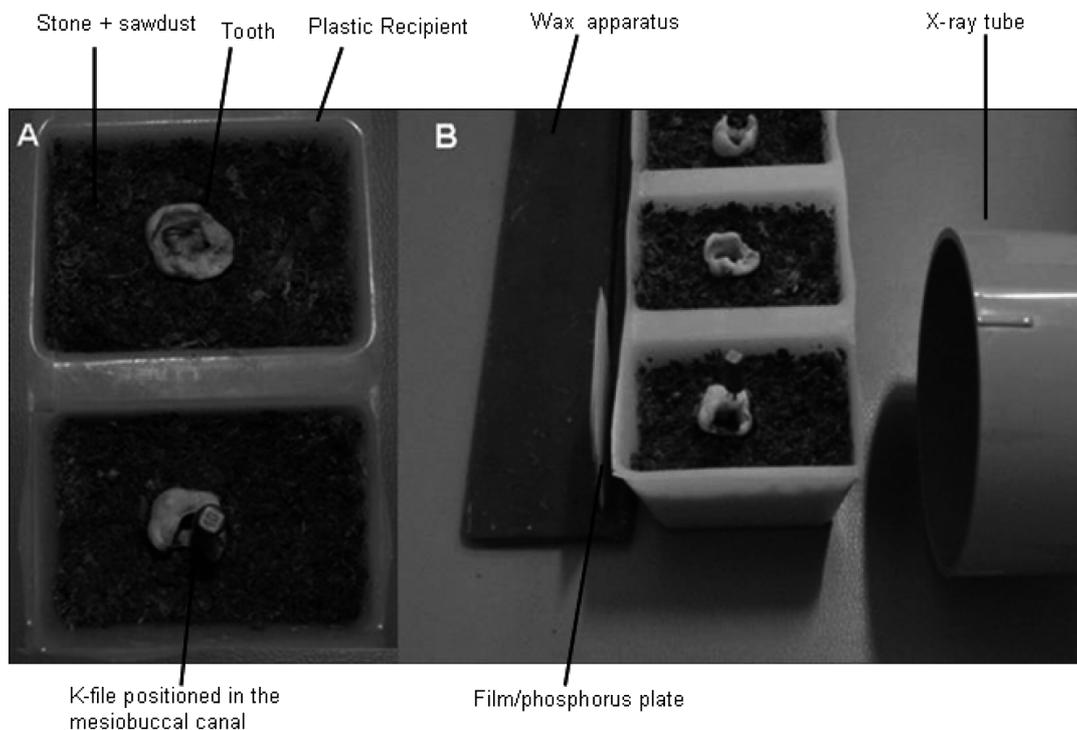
Methodology for acquisition of radiographs. A: The insertion of tooth in a plastic block containing a type III stone plaster and sawdust mixture, B: Standardization of distance and the angle for conventional and digital radiographs.
